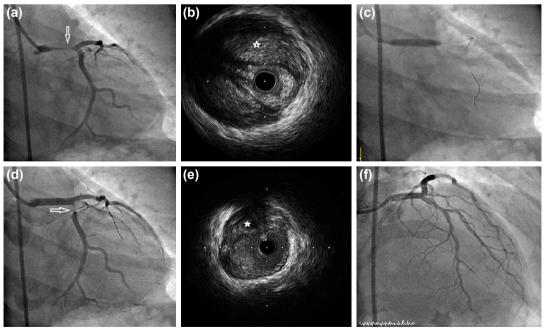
(a) The left main coronary and left anterior descending arteries compressed by the intramural hematoma; (b) Intravascular ultrasound (IVUS) confirmation of the diagnosis; (c) Stenting; (d, e) After stenting, the hematoma shifted the left circumflex (LCX) artery, and (f) the intramural hematoma developed and extended to the LCX artery. The hematoma was confirmed by IVUS. White arrow indicates artery that the intramural hematoma compressed. White asterisk indicates the hematoma identified by IVUS.
